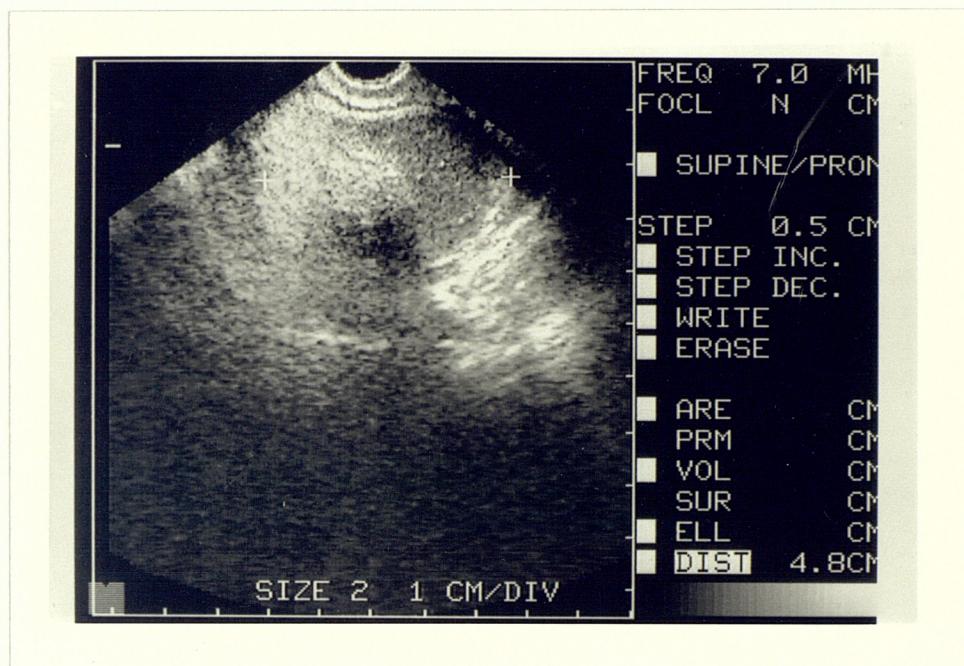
Transvaginal ultrasound of cystic teratoma
